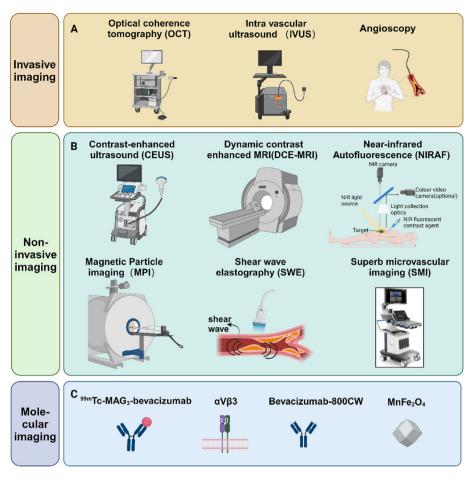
The imaging technique of neovascularization in plaque. (A) Invasive imaging detects the specific characteristics of these lesions using specially constructed high-resolution catheters. Including OCT, IVUS, and angioscopy. $^{1.56}$ (B) Non-invasive imaging has low spatial resolution and can identify pathological features of vulnerable plaques, mainly including CEUS, DCE-MRI, NIRAF, SMI, MPI, and SWE. $^{1.59-164}$ (C) Molecular imaging identifies lesions by increasing the expression of specific markers. This paper mainly introduces $^{99m}\text{Tc-MAG}_3\text{-bevacizumab}$, Integrin $\alpha_V\beta_3$, Bevacizumab-800CW, and MnFe_2O_4. $^{166-170}$ Created with Biorender.com.
